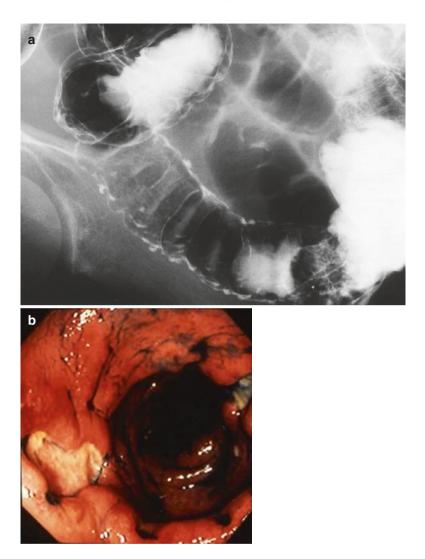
Barium enema X-ray study and colonoscopy images from case 4. (a) Barium enema X-ray study visualizes multiple cuff link-like ulcerative lesions with reduced mucosal folds in the sigmoid colon. (b) Colonoscopy shows multiple irregular-shaped punched-out ulcerative lesions surrounded by edematous mucosa
